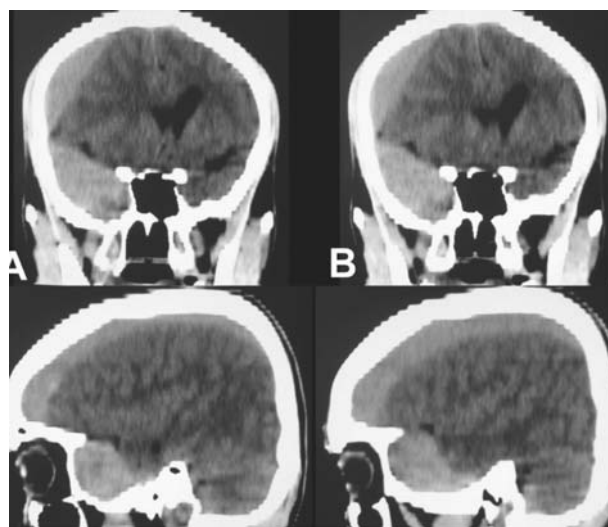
CT scan brain sagittal images showing crescentic hypo- & isodense fronto-parietal and biconvex temporal-sub temporal collections of chronic subdural hematoma
